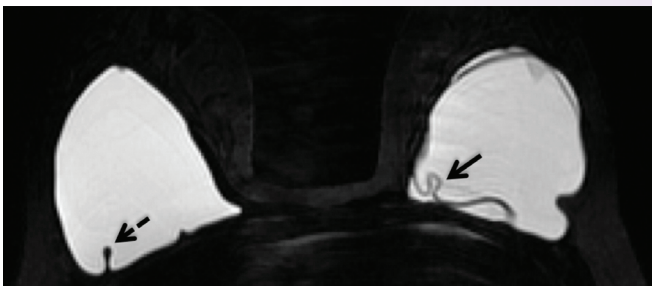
Silicone-selective MRI image showing a simple fold in the elastomer shell of the right implant (dashed arrow) and an intracapsular rupture in the left implant (solid arrow) with fluid outside the folded implant shell.
